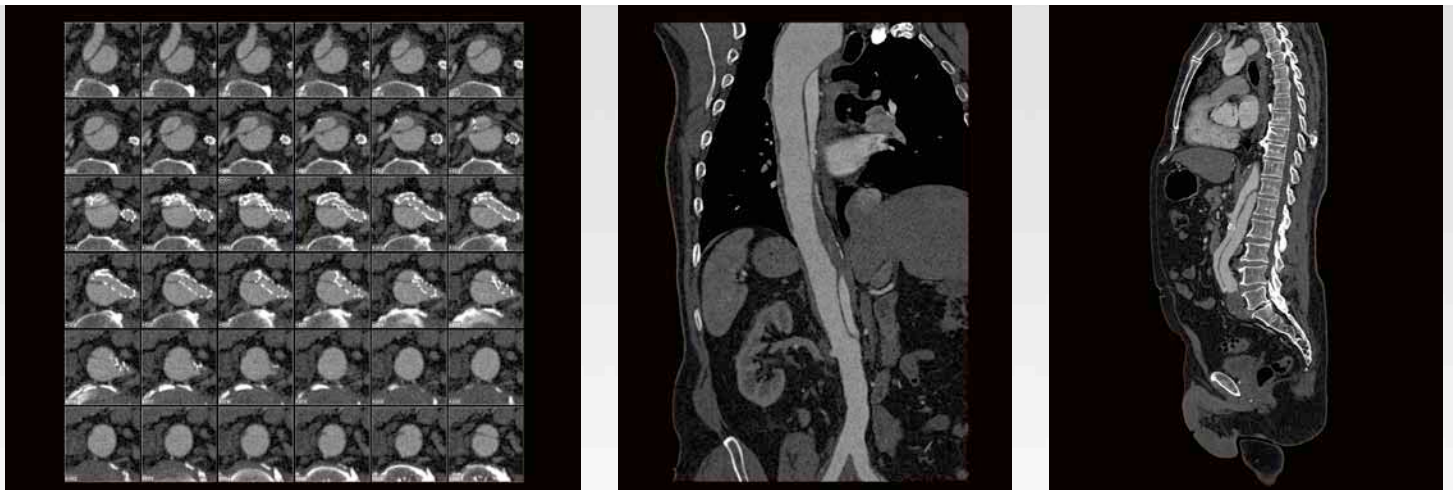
(A, B, C): An extensive dissection of the thoracic and abdominal aortas is visible on the axial, coronal and sagittal CTA images (reconstructed using MIP), also involving the pelvic axis (partially depicted). The visceral vessels and the renal arteries originate from the more narrow true lumen. Two stents were implanted in the left renal artery.
